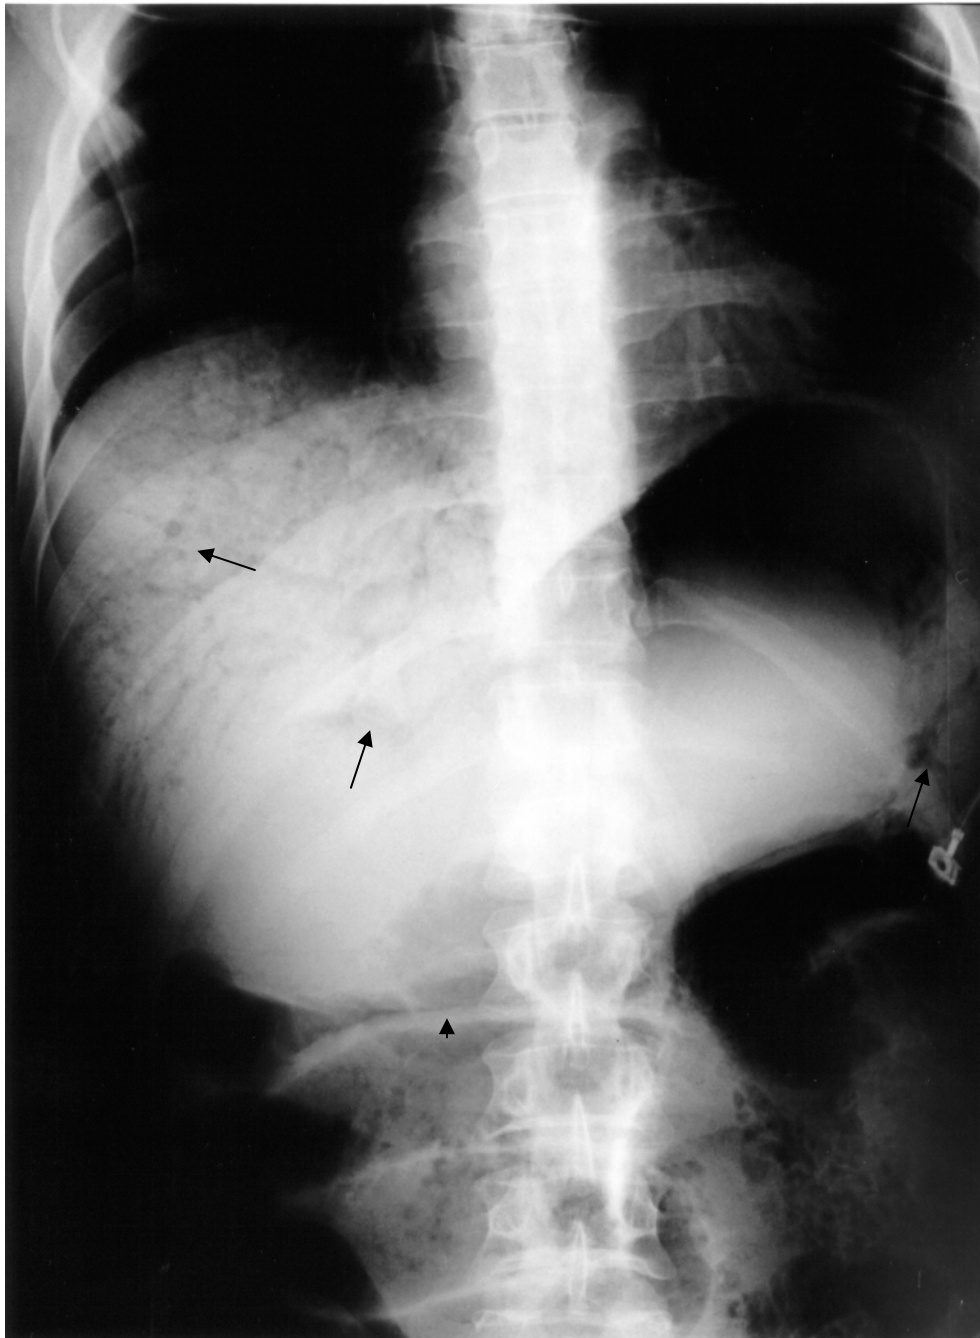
Plain erect abdominal X-ray shows extensive accumulation of gas in the intrahepatic and extrahepatic portal and splenic veins (arrows), and dilated and oedematous small bowel associated with pneumatosis intestinalis (arrowheads).
